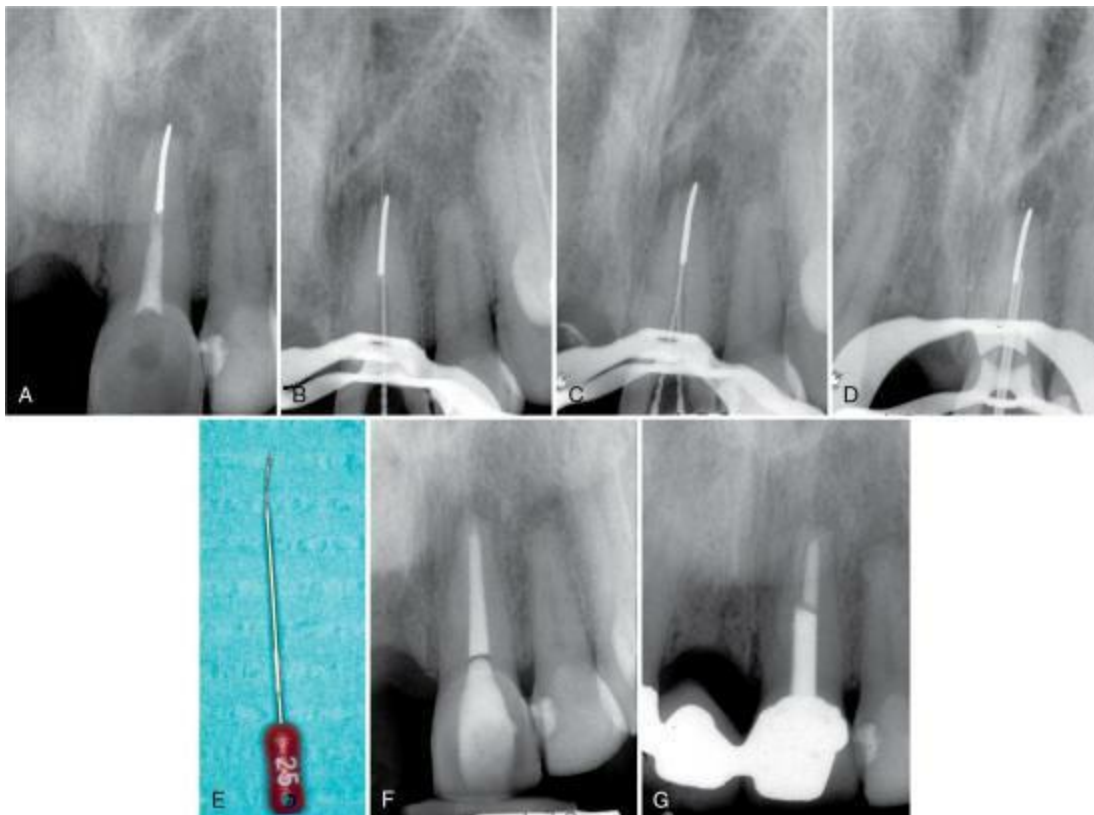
Twist-off silver point case. A, Preoperative radiograph showing apical periodontitis and a split silver cone (“twist-off”) obturation technique. B, The cone was initially bypassed but could not be loosened. C, The braided Hedstrom file technique was attempted but was unsuccessful. D, A Brasseler Endo Extractor tube is cemented to the cone with cyanoacrylate cement. This instrument is no longer on the market. E, The silver point is removed. F, Immediate postobturation radiograph. G, One-year follow-up showing apical healing.
